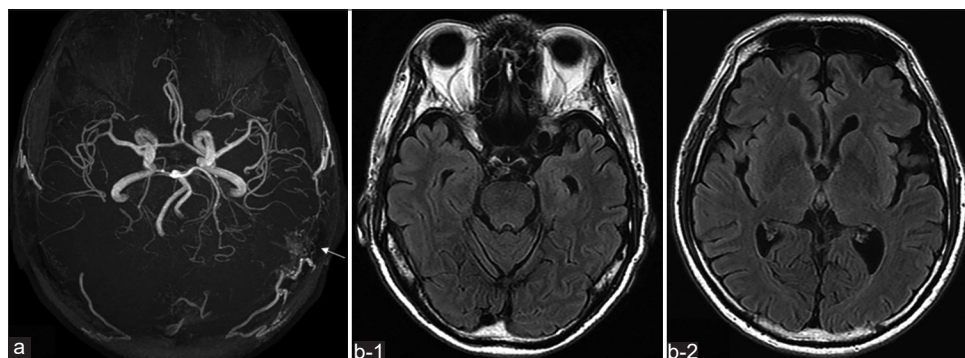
Magnetic resonance imaging on admission. (a) Magnetic resonance angiography shows abnormal clusters of numerous blood vessels in the area of the left transverse sinus-sigmoid sinus junction (white arrow). (b) Fluid-attenuated inversion recovery imaging reveals no abnormal changes.
